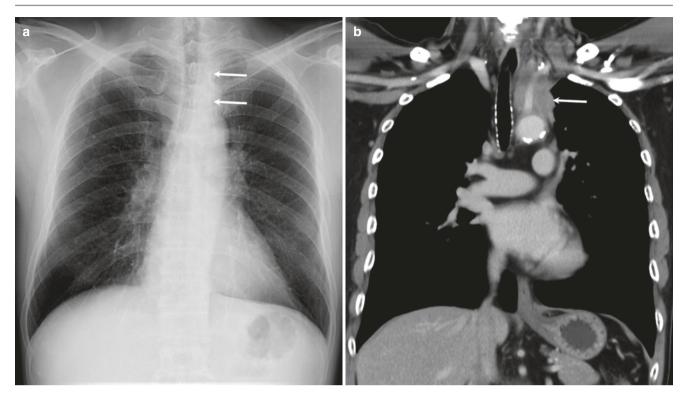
61-year-old man with left upper lobe bronchogenic carcinoma. (a) Frontal radiograph shows thickening of the left paratracheal stripe (arrows) with fuzzy outlines and displacement of the trachea
